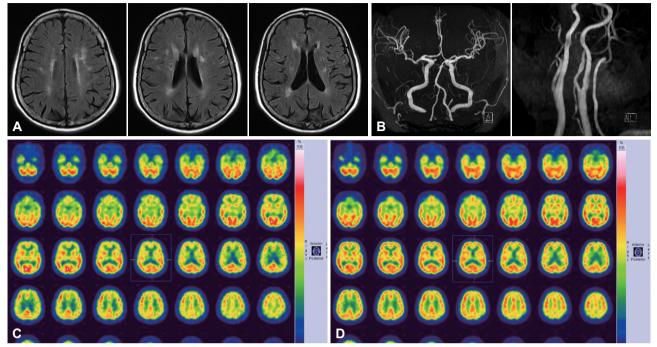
Magnetic resonance imaging of the patient's brain showed multiple hyperintensities in subcortical white matter (A) and magnetic resonance angiography showed no definite intracranial and extracranial stenoses (B). ^{99m}Tc-ethylcysteinate dimer single photon emission computed tomography scan of the brain at baseline (C) and after acetazolamide (D) showed a decrease in cerebral blood flow in the left parietal cortex without vascular reserve.
